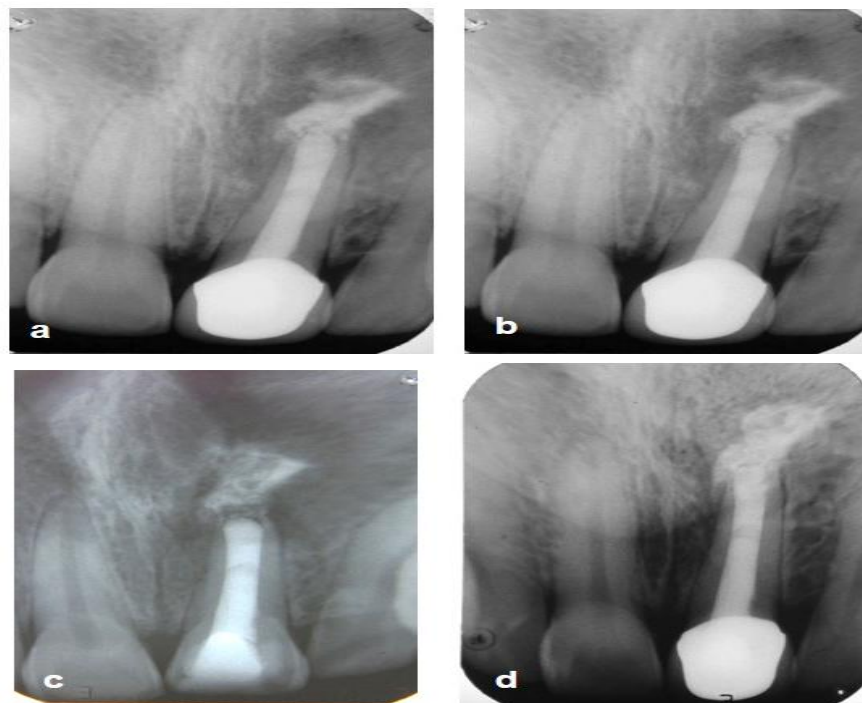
Post operative radiograph showing (a) three month follow up; (b) Six month follow up; (c) one year follow up showing bone formation and the compression of MTA; (d) 4 year recall showing complete healing of periapical lesion around the extruded MTA
